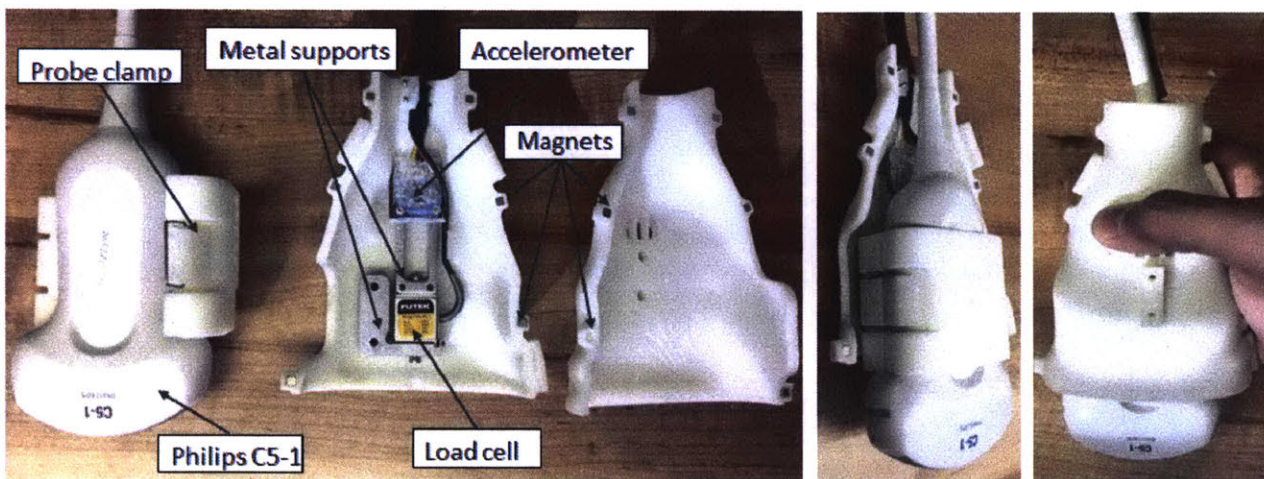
Hardware to record force-correlated ultrasound images and elastographs
